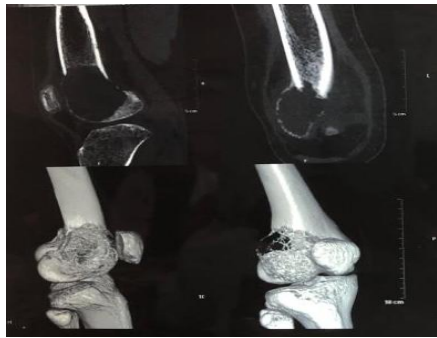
CT Scan showing GCT of distal femur
